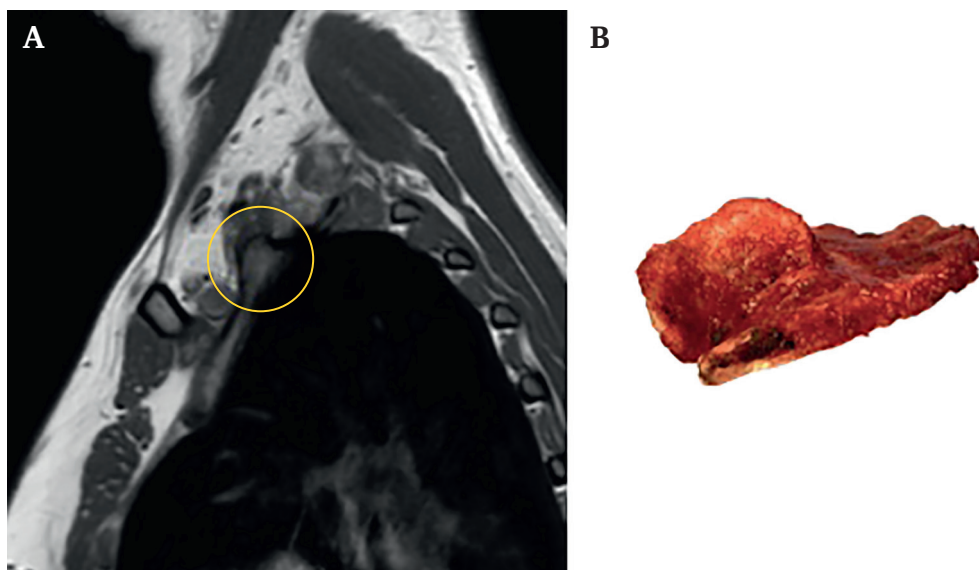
(A) Sagittal view of chest magnetic resonance imaging. Anomalous first rib (osteophyte). (B) Sagittal view of resected first rib. It is possible to see an osteophyte.
